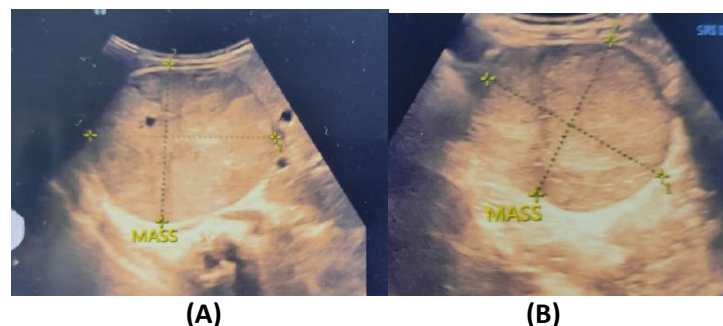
Ultrasonography showing right (A) and left (B) renal solid mass
